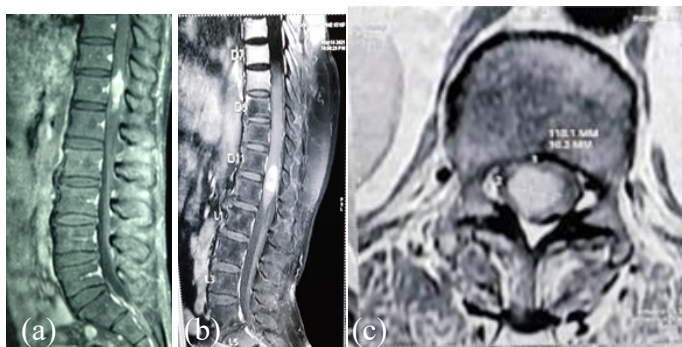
(a) T2W MRI view showing a mixed intensity lesion at conus with significant perilesional edema; Post-contrast sagittal (b) and axial (c) T1-weighted magnetic resonance (MR) images revealing an enhancing conus lesion, measuring 23.7×9.4 mm.
